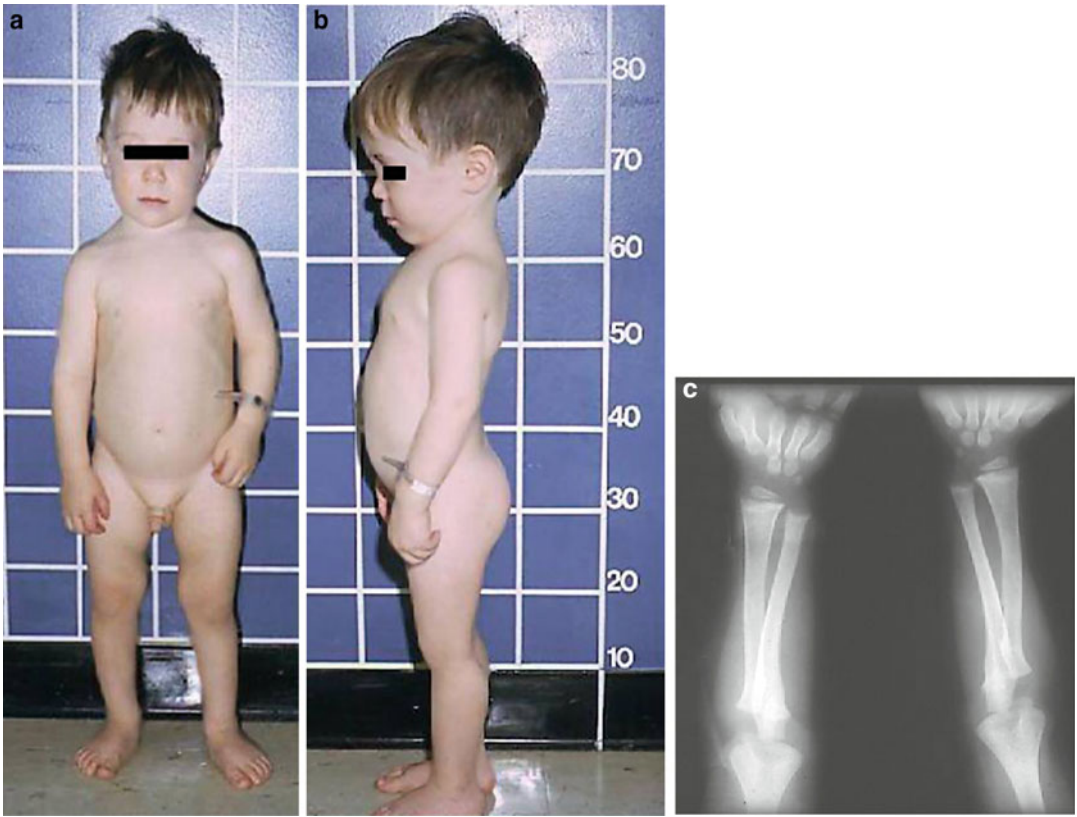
(a–c) A boy with vitamin D-resistant rickets showing short stature (a, b). The radiograph (c) shows widening, cupping, and fraying of the distal radius and ulna
